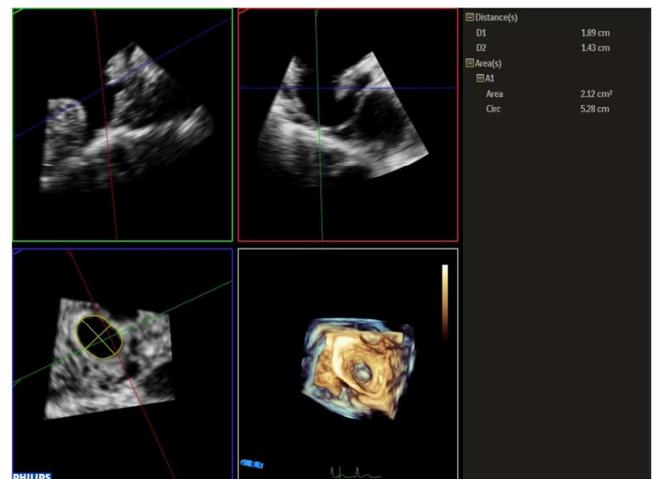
Echocardiographic image of the left atrium.
